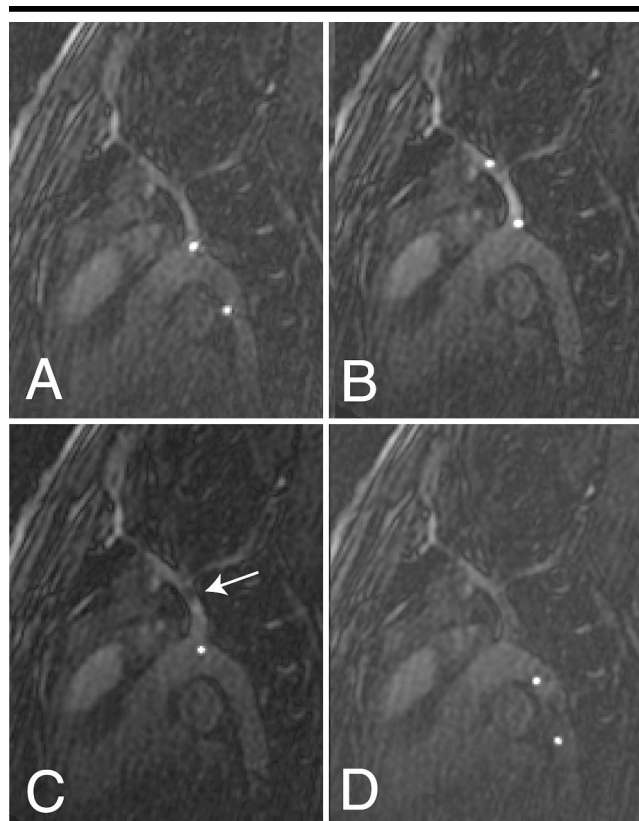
Parasagittal interactive steady-state free precession (2.9/1.6; flip angle, 5°; section thickness, 8 mm; acquisition frame rate, 8 per second; field of view, 280 mm; matrix, 128 × 128) MR images of the thoracic aorta, carotid artery, and SDS with single RCs show good contrast between SI of RCs and SI of background anatomy achieved with flip angle of 5°. A, Advancement of the SDS through the aortic arch. B, SDS in the carotid artery immediately before stent delivery. C, Release of the nitinol stent accompanied by detuning of the distal RC (arrow). D, Retraction of the SDS into the descending aorta.
